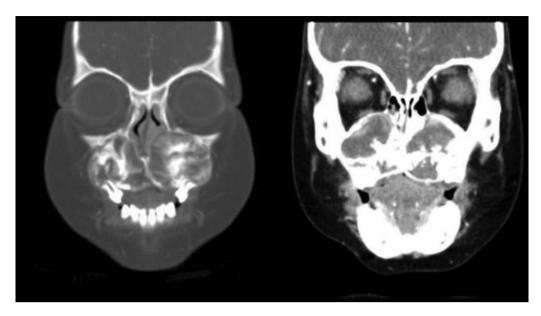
Preoperative coronal computed tomography scans showing two expansile mass lesions involving nearly entire maxilla bilaterally.
